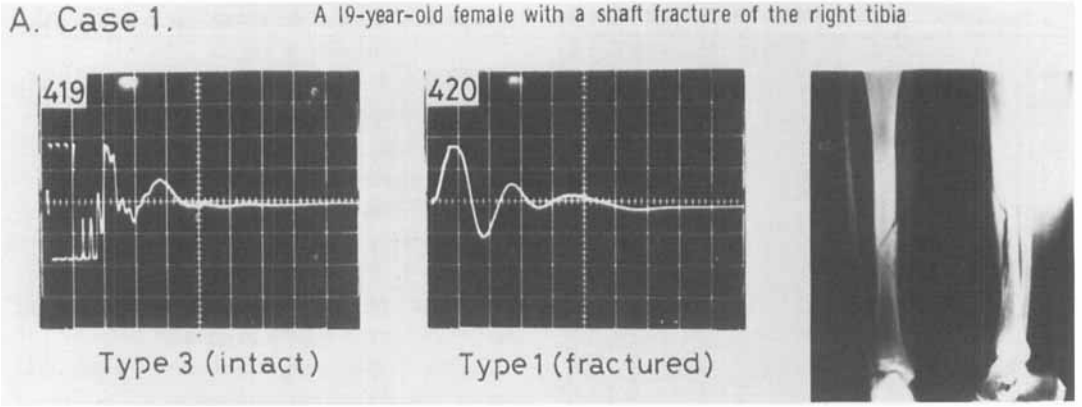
The signal waveform of the p-note of fresh fractures and their corresponding X-rays.
